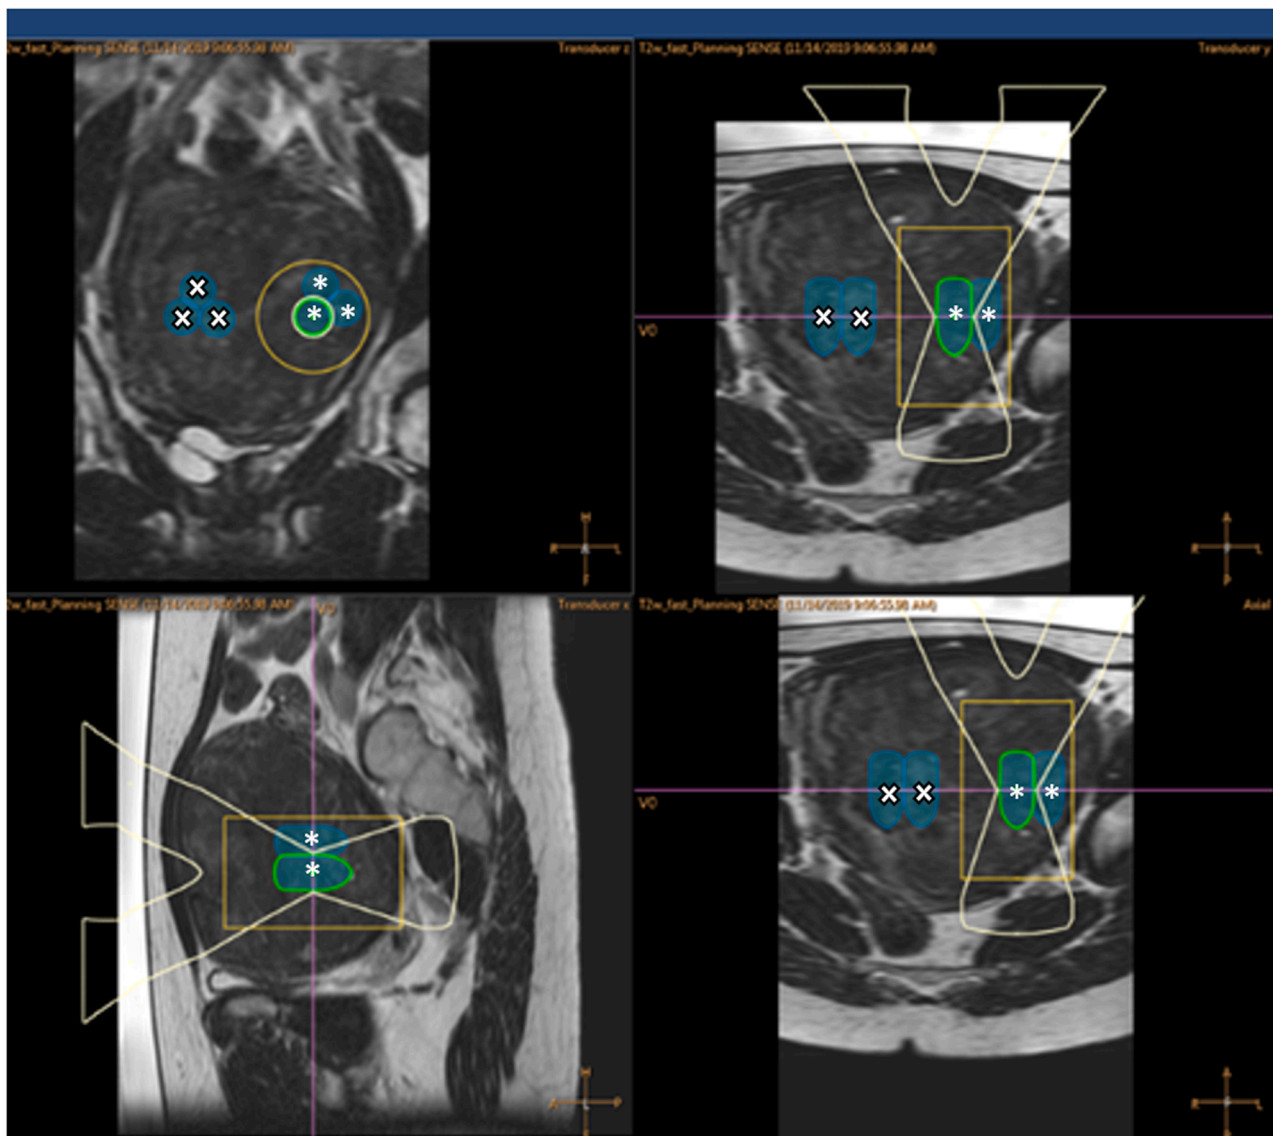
Screenshot of the Sonalleve MR-HIFU therapy application-planning screen with sonications planned on T2w MRI-scan images. description: During treatment preparation, the uterine fibroid is displayed in three directions; top left coronal direction, top and bottom right axial direction and bottom left sagittal direction. The three sonications (blue shaped, sized 16 mm) before carbetocin administration are marked with white asterisks and placed on one side of the uterine fibroid. The three sonications (blue shaped, sized 16 mm) after carbetocin administration are marked with white crosses and placed on the other side of the uterine fibroid. The selected sonication is illuminating in green and the borders of the ultrasound beam are displayed in yellow in all three directions.
